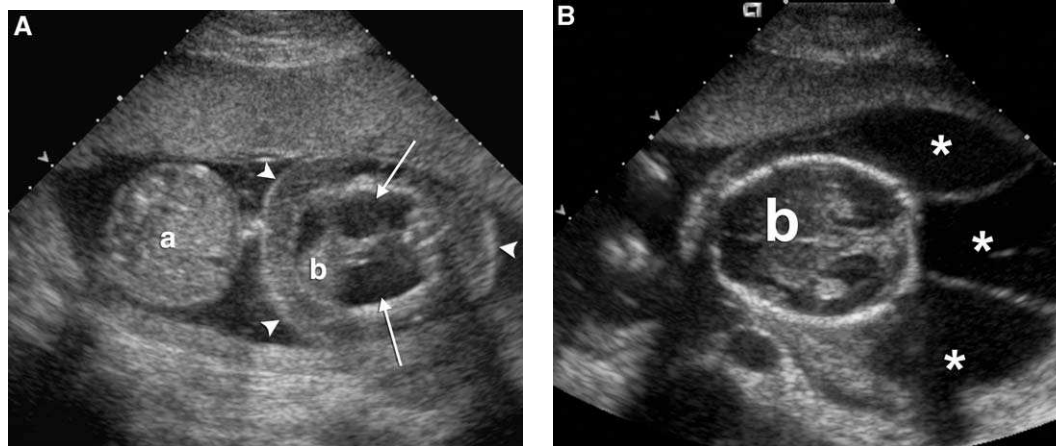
Monozygotic twin pregnancy discordant for major anomaly. (A) Transverse sonogram through the abdomen of the normal twin (a) and the thorax of the affected twin (b). This is not a case of twin-twin transfusion syndrome or acardiac, parabolic twin. Amniotic fluid volume was normal for each twin, and twin B was shown to have a beating heart with normal flow direction in its umbilical artery. Twin B has diffuse lymphangiectasia with integumentary edema (arrowheads) and bilateral pleural effusions (arrows). (B) On another image of twin B, multiple large cystic hygromas (\*) are shown.
